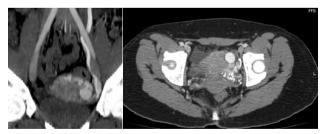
CT angiography images confirm AVM with dilated left ovarian vein (seen in coronal reformatted MIP-ped image. Axial image shows tortuous dilated vessels in left fundal region with aneurysm.
